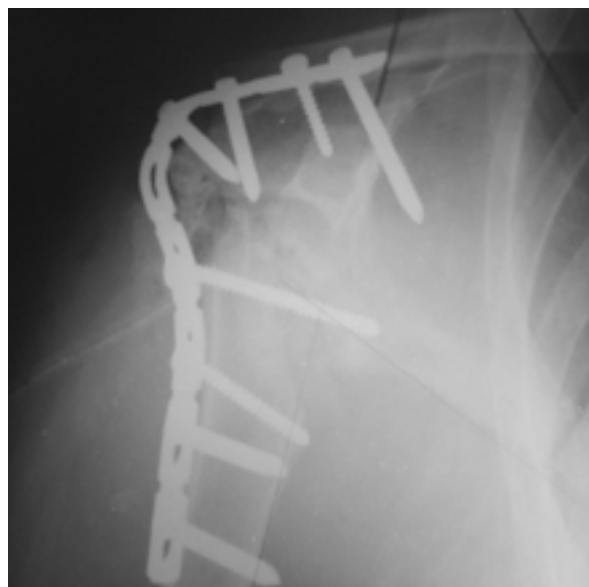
anteroposterior radiograph of the shoulder shows signs resorption of the graft and the humeral head and destructive joint changes
